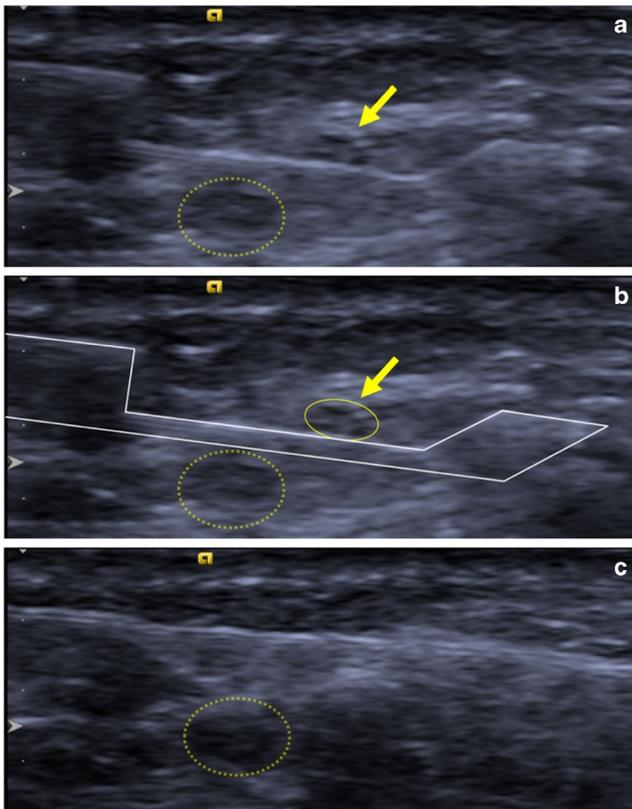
a, b Transverse ultrasound images show the sural nerve (*arrow*, *solid circle*) positioned within the biopsy needle tray excluding the adjacent small saphenous vein (*dashed circle*). c The needle was angled slightly superficially and fired
